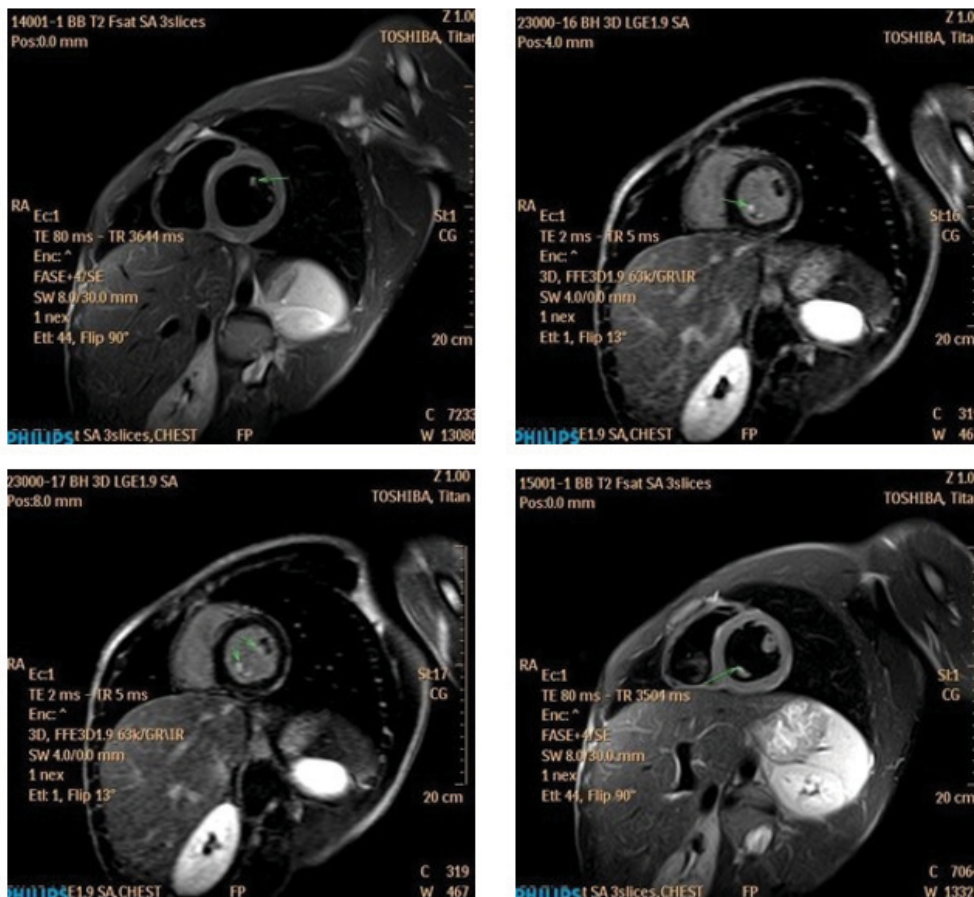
CMR scan done at 14 days. LGE and T2-weighted sequences showing edema at the distal portion of the left ventricular papillary muscles (arrow).
